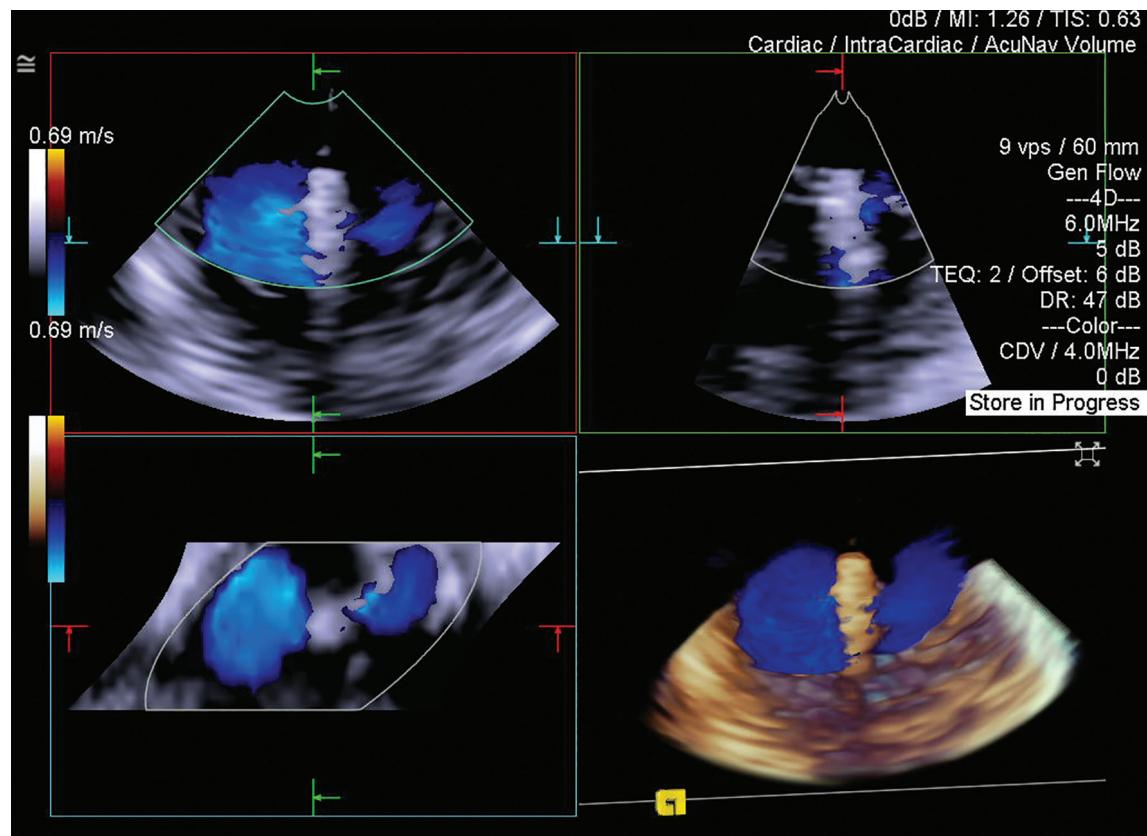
Following MitraClip deployment, 4D volume color Doppler reveals a residual double orifice with forward flow.
